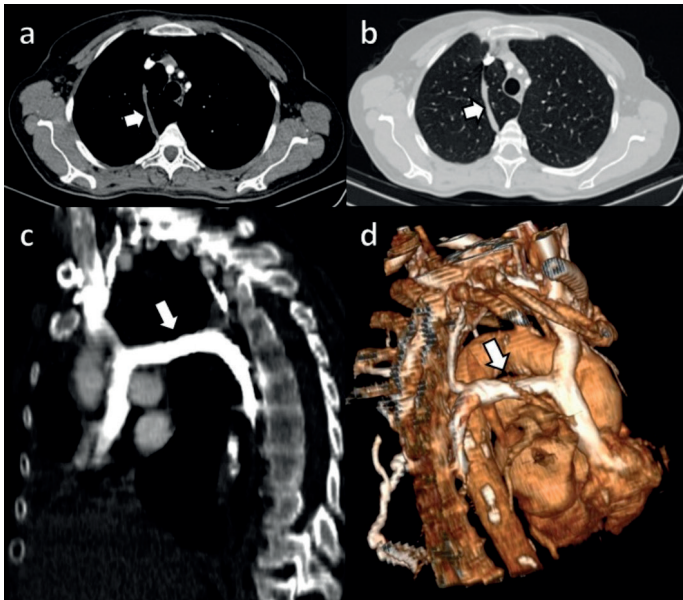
Axial contrast enhanced thorax CT mediastinal and parenchyma window images (a, b) of azygos vein (white arrows), azygos fissure and azygos lobe. MPR sagittal image (c) and 3D reformat image (d) show azygos arch (white arrow).
